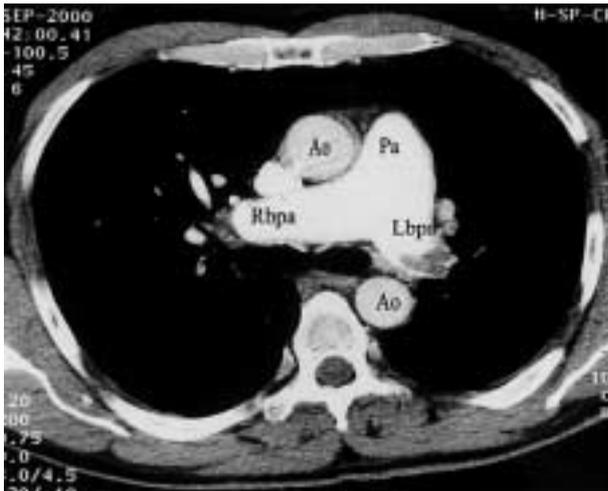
Spiral CT image confirming enlarged pulmonary artery and branches with thromboembolic material. Ao = Aorta, Pa = Pulmonary Artery, Rbpa = Right branch of pulmonary artery, Lbpa = Left branch of pulmonary artery.
